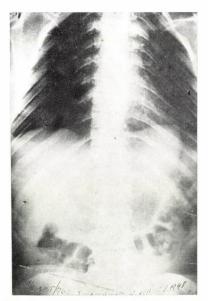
Roentgenogram of thoracal spine
